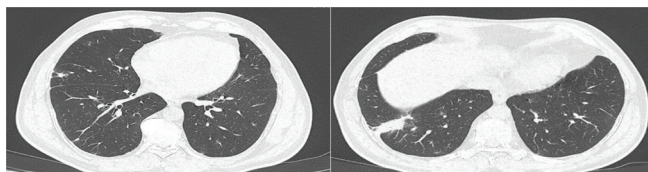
CT scan of the chest highlighting the almost complete resolution of the nodular and micronodular lesions.
